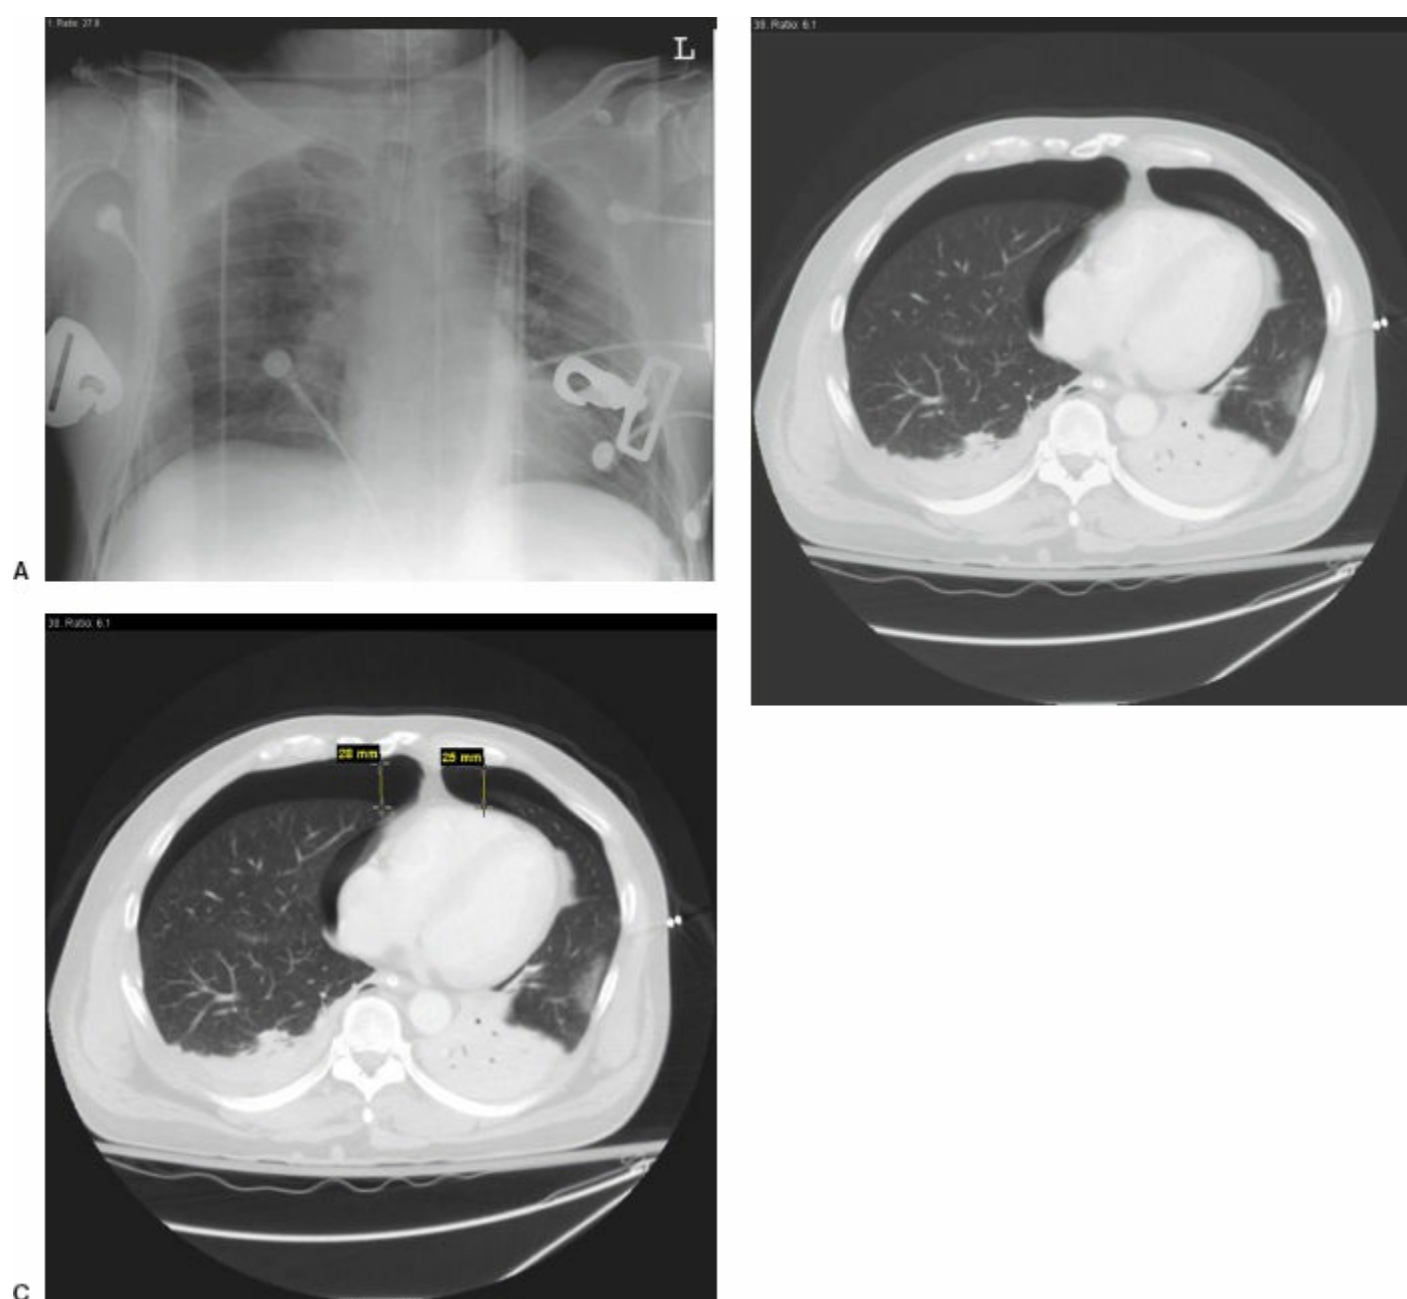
A: AP CXR in trauma bay with no evidence of pneumothorax. B: Occult pneumothorax seen on CT scan C: Measurement of largest air pocket in a line drawn perpendicular to the chest wall.
